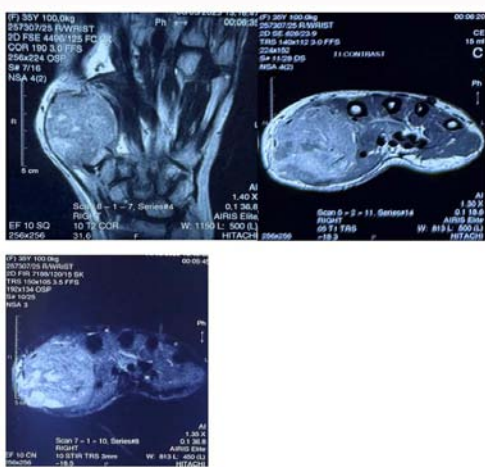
Pre-treatment MRI in T2 coronal (a), T1 (b) and STIR (c) sequences.
